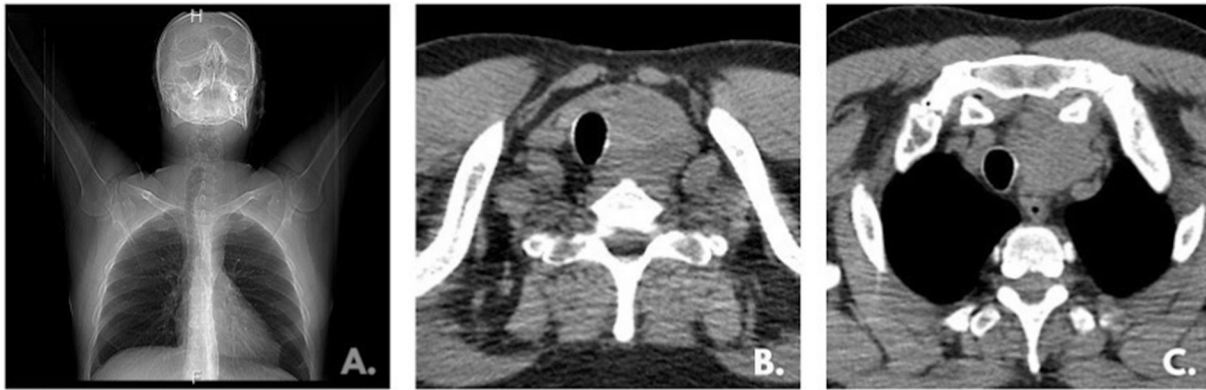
Computed tomography. It revealed a large tumour formation measuring 80/50 mm, emanating from the left lobe of the thyroid gland (B, C), the lower pole of which is located in the upper mediastinum and pushes the left brachiocephalic vein ventrally. The trachea is displaced contralaterally (A).
